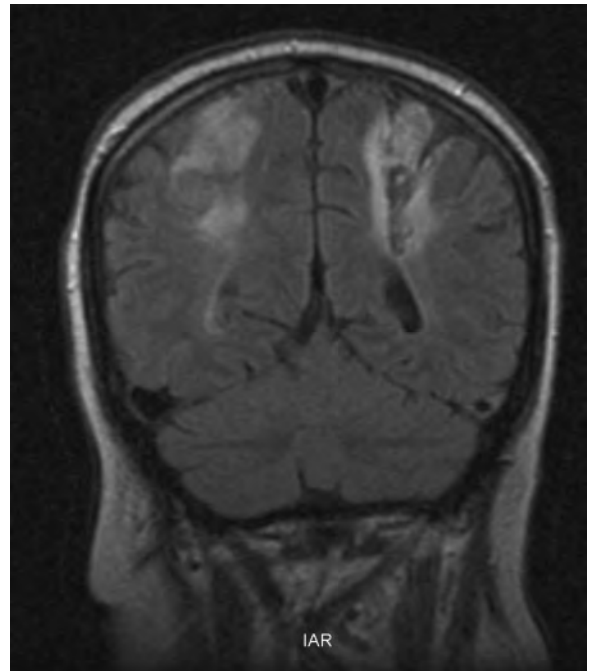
Border-zone infarction following carotid occlusion (Coronal MR FLAIR image).
